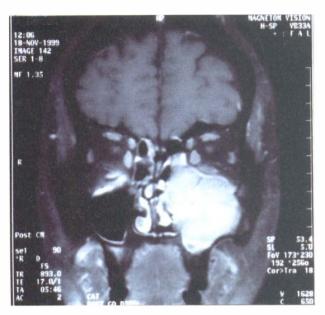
Coronal MRI scan of the orbits and maxillary sinuses showing a mass filling the left maxillary sinus and eroding through the left orbital floor to displace the globe.
